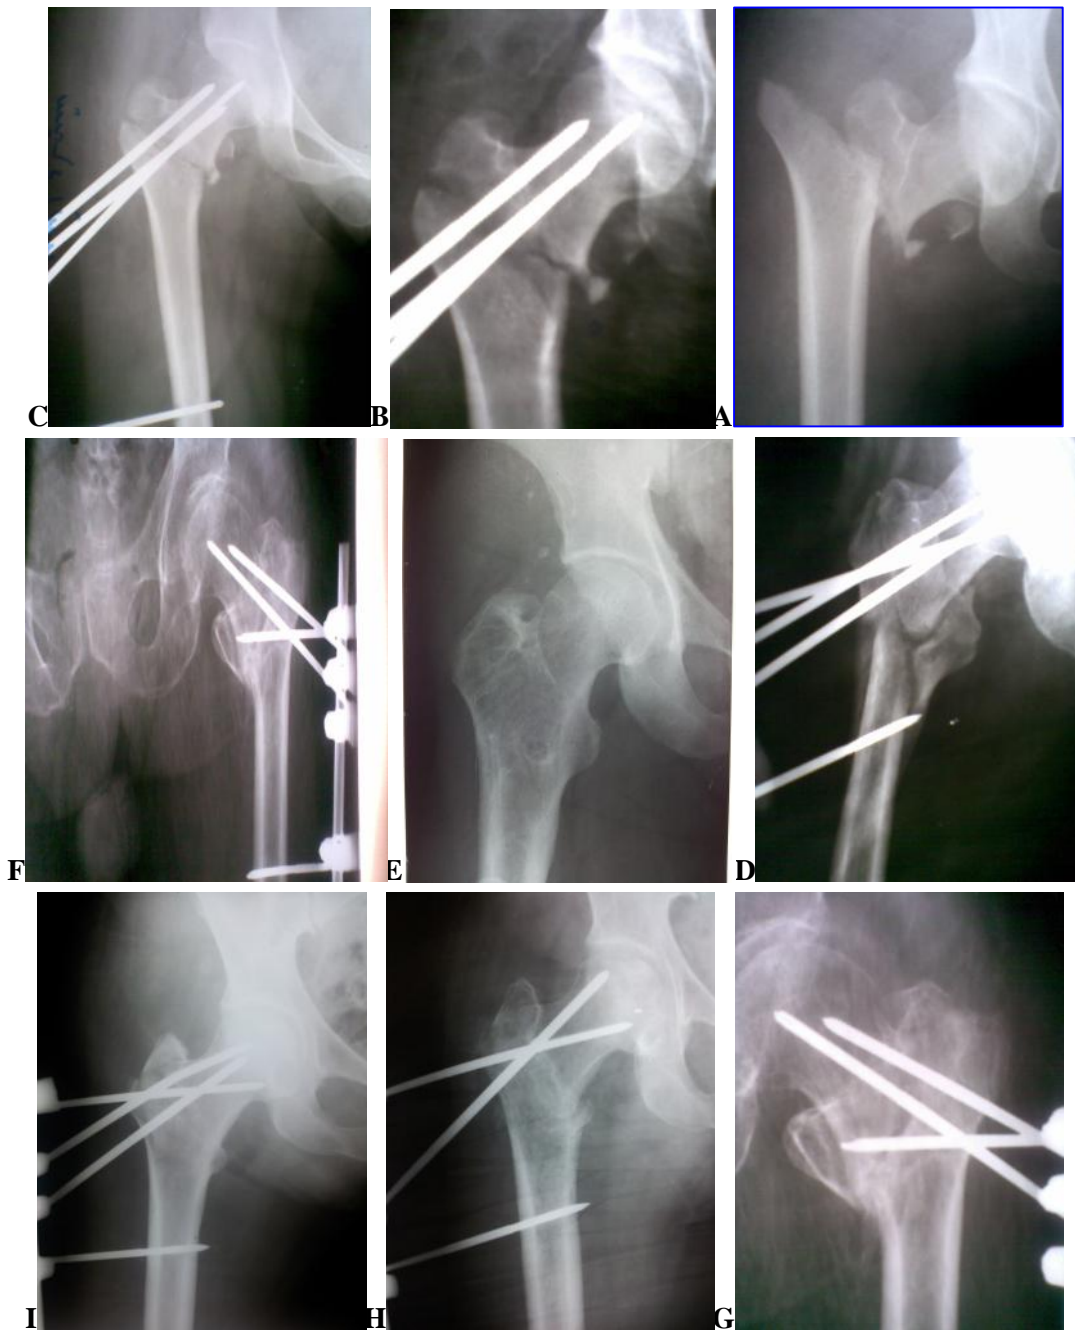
a. Preoperative high velocity fracture with contra lateral distal femur fracture b. immediate postoperative x-ray , unstable intertrochanteric fracture fixed with external fixation.c.4 weeks later, the fracture in stage of union. d. unstable intertrochanteric fracture in 35 years patient ,with high energy trauma, this x-ray show anatomical reduction & fixation e. this x-ray for fracture (d), taken 12 months after removal of external fixator showing excellent healing (F,G,H and I ), geriatric fractures fixed with external fixation taken 8 & 10 weeks shows bone healing in progress.
